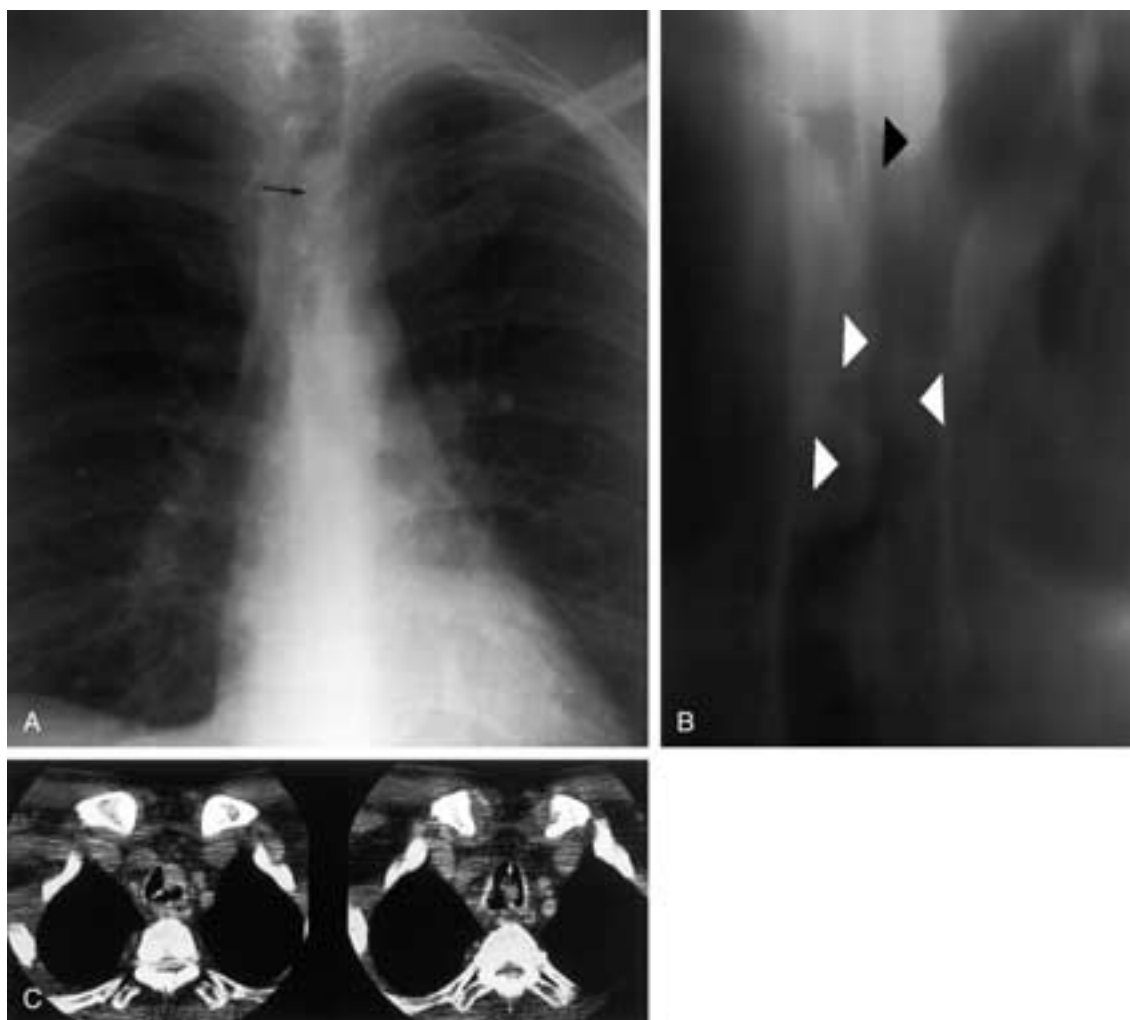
Tracheal papillomatosis. A, Anteroposterior chest radiograph demonstrates multiple exophytic masses projecting into the tracheal lumen (*arrow*). B, Coronal plain film tomography demonstrates multiple polypoid masses arising from the tracheal wall (*arrowheads*). C, Axial contrast-enhanced CT scan through the midtrachea demonstrates multiple pedunculated and broad-based exophytic polypoid masses arising from the tracheal wall (*arrows*).
